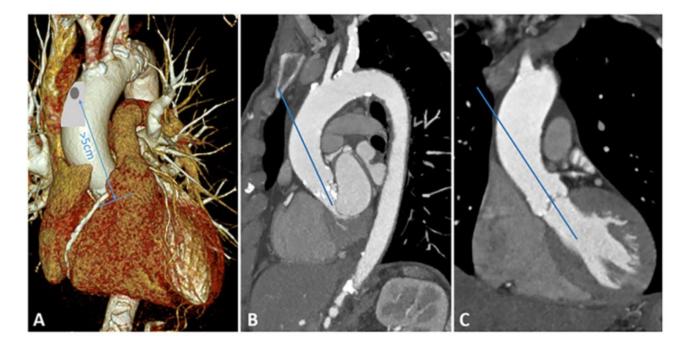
Preoperative multislice computed tomography scan. (A) 3D reconstruction of the aortic arch, appropriate location for aortic puncture is highlighted in gray. The distance between the puncture and the aortic annulus should be at least 5 cm. (B) Sagittal plane of the aortic arch. (C Coronary) plane of the ascending aorta (14).
